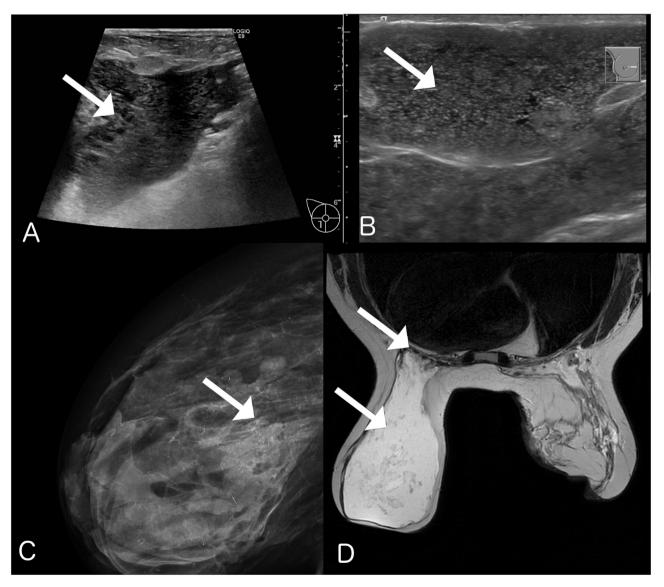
A: Ultrasound of right breast showing diffuse PAAG in the subcutaneous tissue and breast tissue (Arrow). B: Ultrasound of the left breast showing homogeneous distribution and intact skin (Arrow). C: X-ray of the right breast showing microcalcification in the remaining mammary tissue (Arrow). D: T2-weighted MRI-scan showing distribution of PAAG in both breasts and diffusion through m. pectoralis bilaterally (Arrow).
